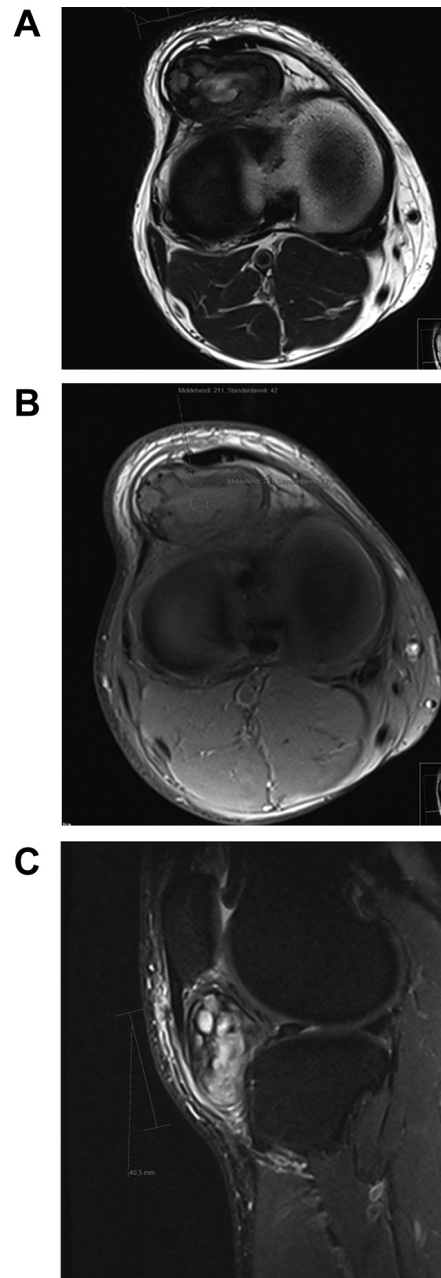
Magnetic resonance imaging of the knee showing an expansive and ill-defined lesion in the infrapatellar fat pad consistent with Hoffa's disease. Axial T2-weighted (A) and axial T1 postcontrast fat-suppressed (B) images demonstrated a heterogeneous lesion with areas of T2 hypointensity and no contrast enhancement, suggesting fibrotic tissue or hemosiderin deposits, and areas with T2 hyperintensity with no contrast enhancement, indicating cystic or myxoid components. C: Sagittal short tau inversion recovery image revealed diffuse edema around the lesion involving the entire Hoffa fat pad and subcutaneous tissue.
